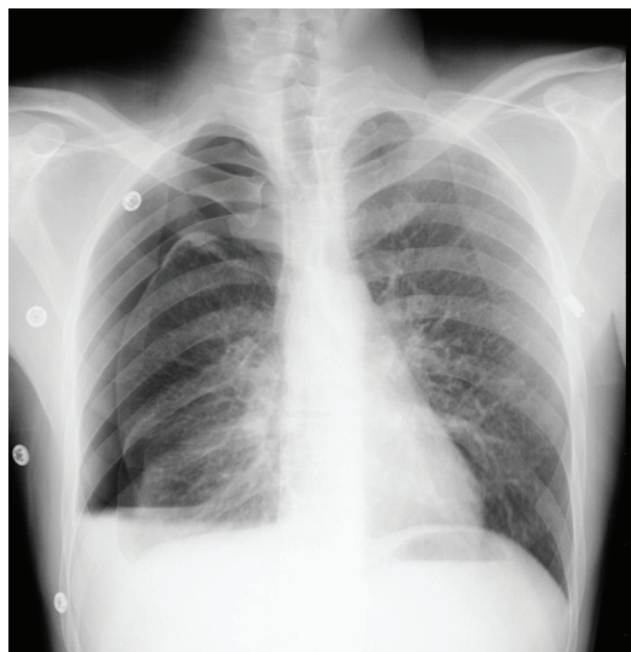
A chest X-ray showing spontaneous hemopneumothorax with air fluid level
